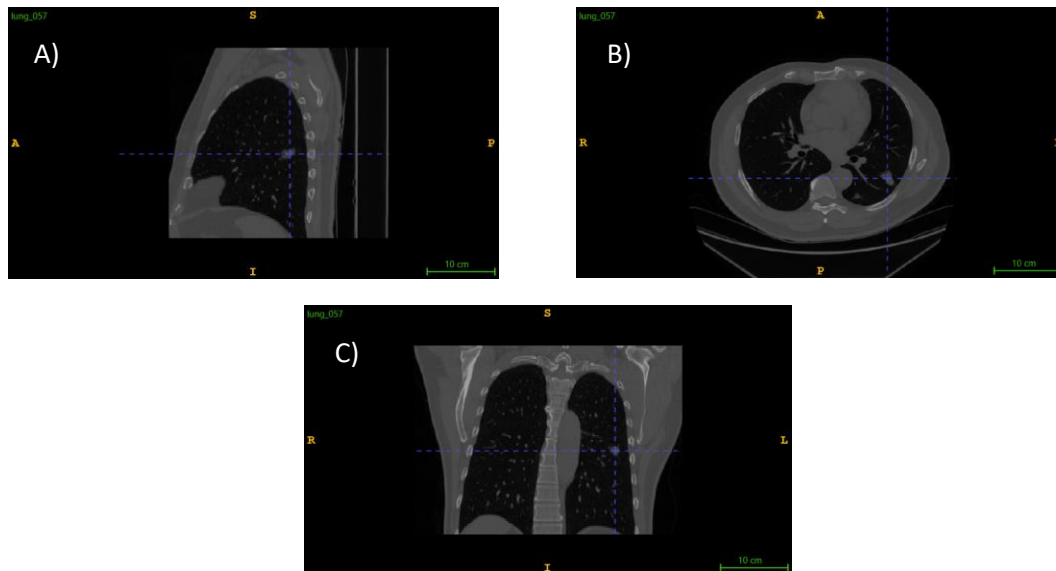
Sample images taken from lung_057 nifti file sample of a CT scan from Medical Decathlon Segmentation website, there were screenshot by ITK-SNAP app, (a) Axial display, (b) Sagittal display, and (c) Coronal display.
